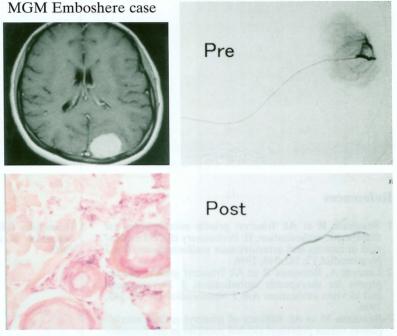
Clinical case: Meningioma; embolism using Embospheres. MRI showed a well-demarcated mass. Pre-angiograms showed a 'sun-burst' phenomenon. Postembolization angiograms showed a complete embolization. Pathological findings showed that there are more Embospheres in the more peripheral artery compared with the PVA cases.
